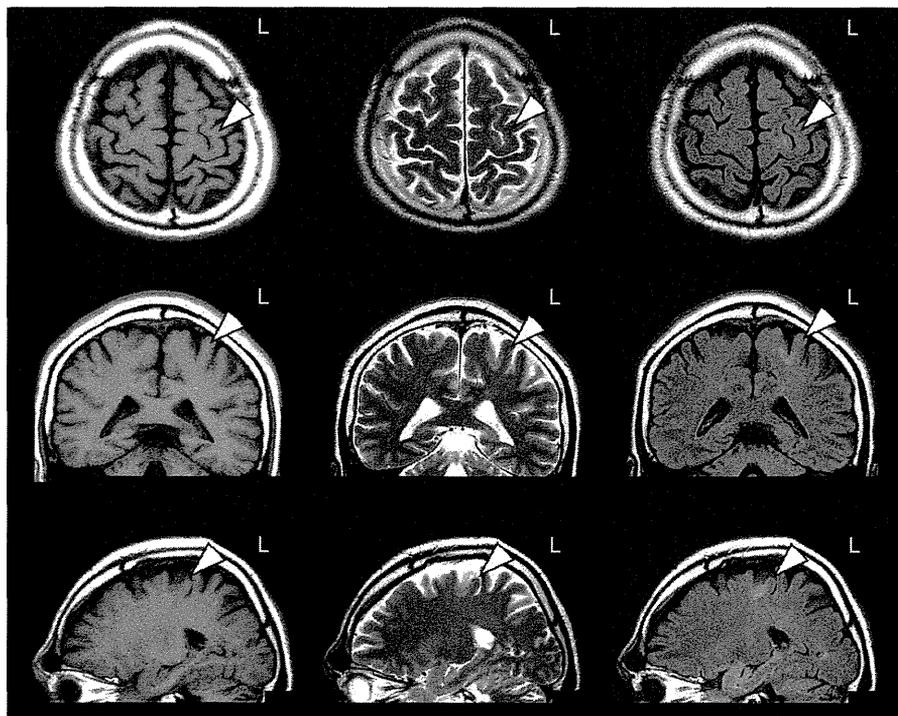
1.5-T MRI of the brain. FLAIR, T1-, and T2-weighted images showed a high intensity lesion, regarded as focal cortical dysplasia, located in the cortex of the posterior portion of the left superior frontal sulcus.
